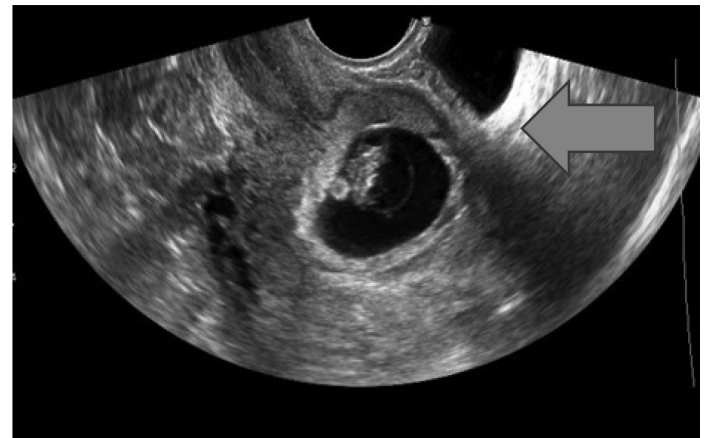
Transvaginal ultrasound at 7 weeks and 3 days showing an anteverted uterus with gestational sac at the anterior myometrium at the level of uterine isthmus at the site of cesarean scar.
